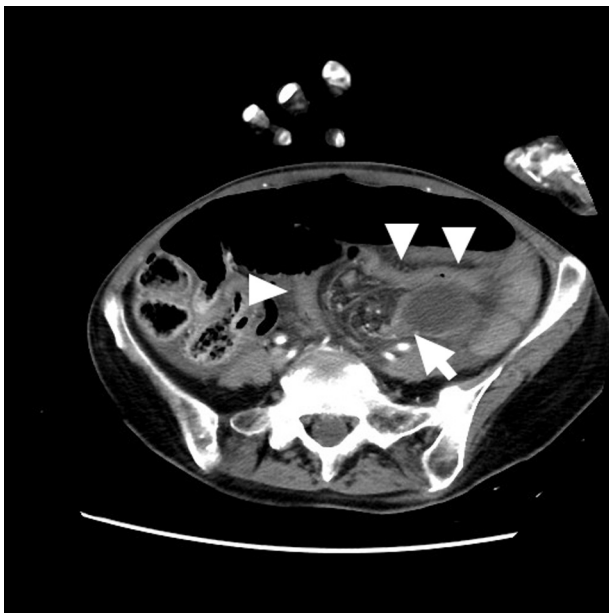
Computed tomography showing the transition zone (arrow) in the left lower abdomen. There is significant surrounding mesenteric fat stranding. Arrowheads indicate sigmoid colon.
